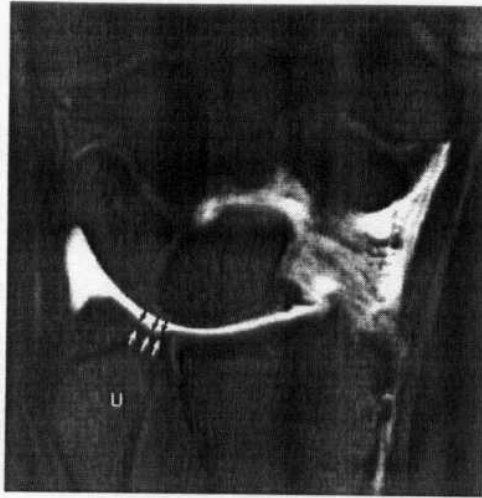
Class IIA lesion with degenerative thinning (arrows) of the TFC without perforation. No lunate chondromalacia is present and the LT ligament is intact. Fat-suppressed T1-weighted coronal MR arthrographic image. U, ulna (Quoted from Stoller and Brody, 1997).
